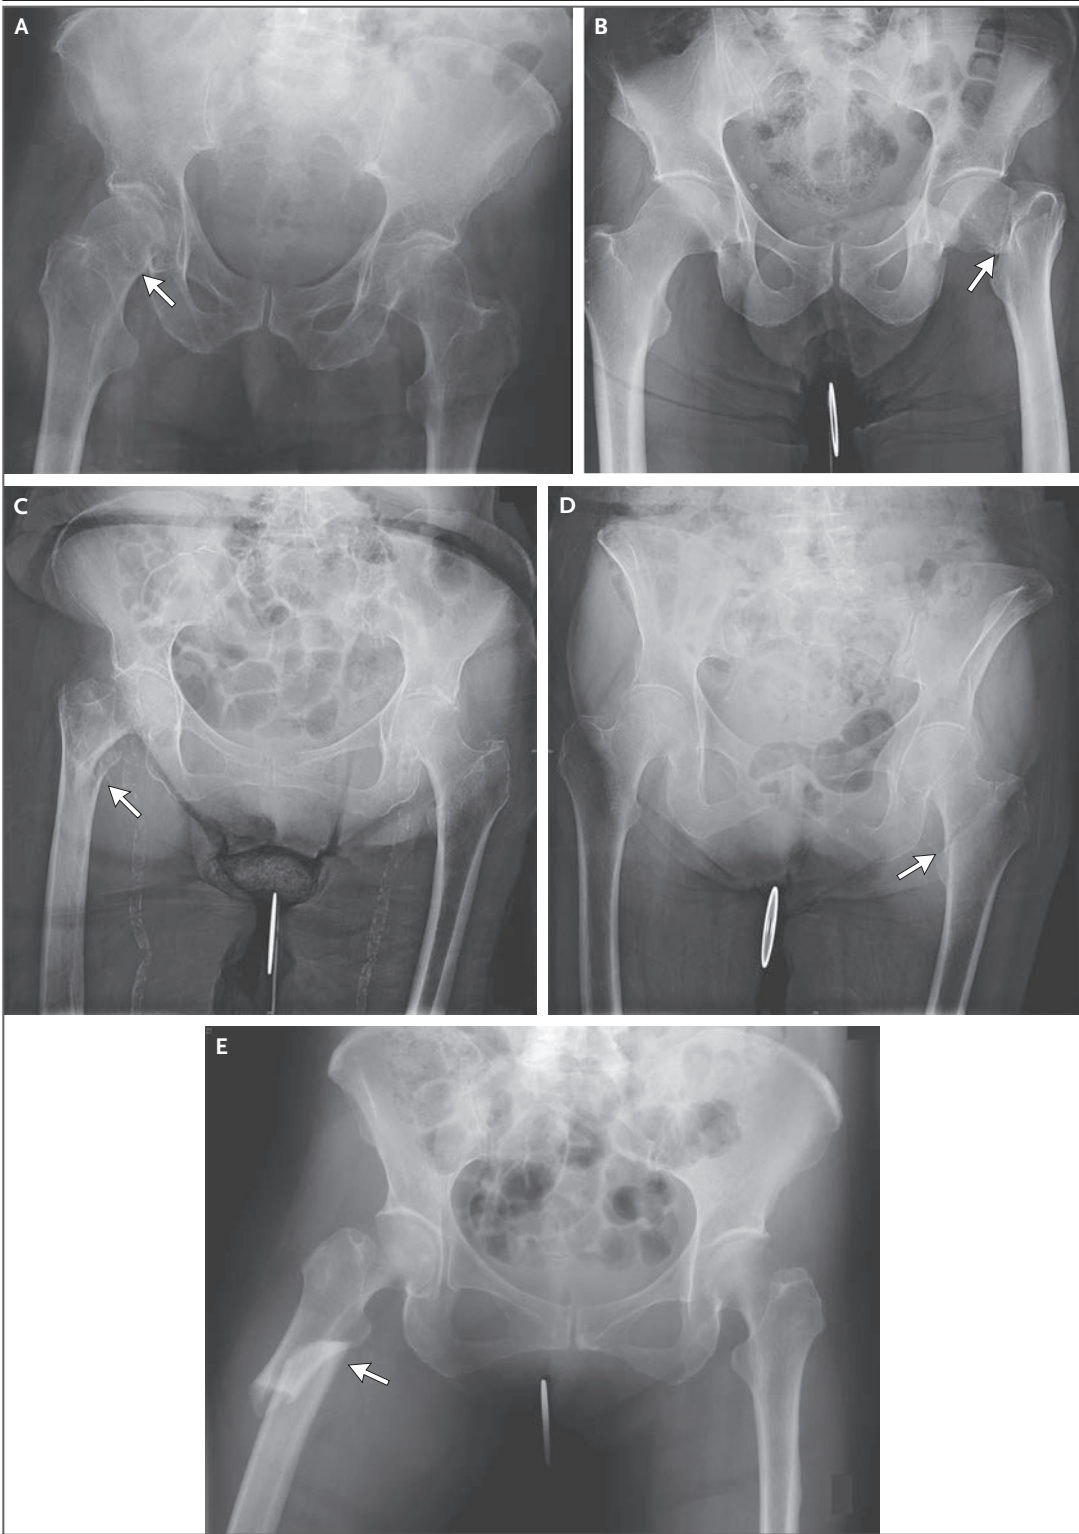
Plain Films Showing Various Types of Hip Fractures.
